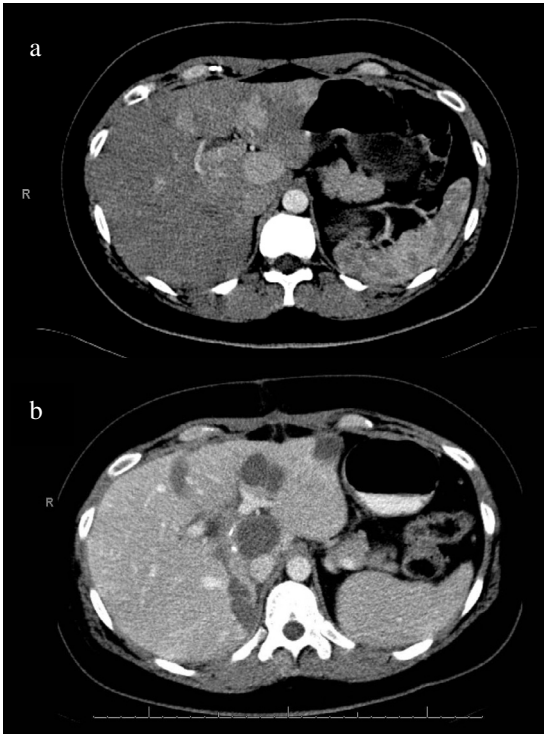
CT image of multiple HCA lesions 6 months before (a) and 2 weeks after (b) first RFA.
